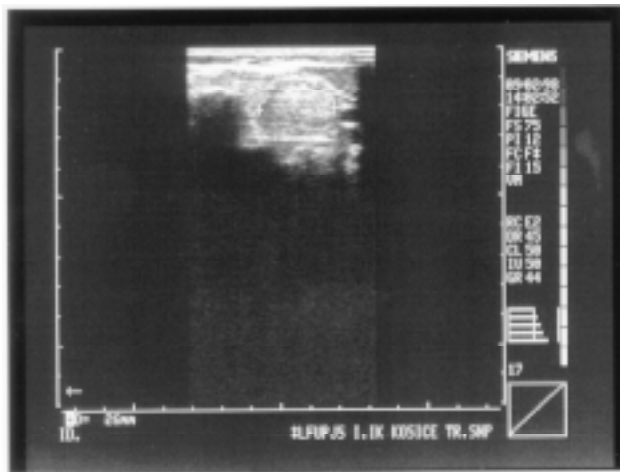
Ultrasound scanning of the thyroid. Solitary nodule in the thyroid.
